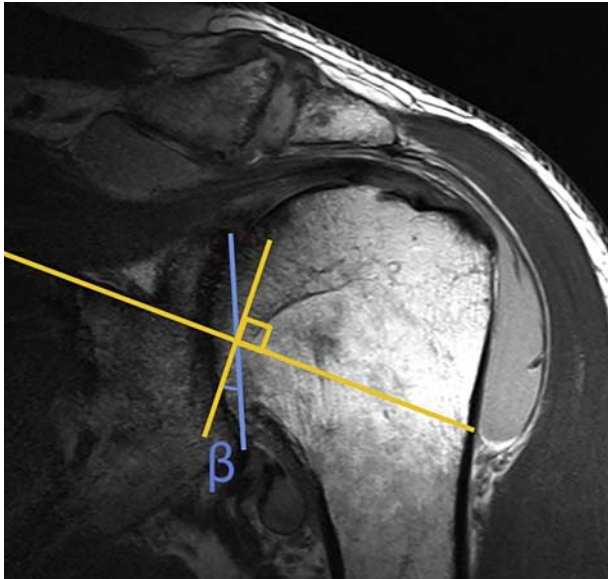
Coronal magnetic resonance image of a preoperative B2 glenoid. Glenoid inclination (β) was measured as the angle between a line perpendicular to the sclerotic line of the supraspinatus fossa and the glenoid fossa line.^{3,15}
